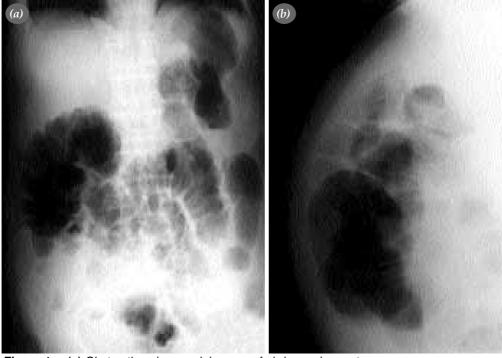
(a) Obstruction sign on plain x-ray of abdomen in erect (b) Lateral decubit position showed fluid accumulation.
